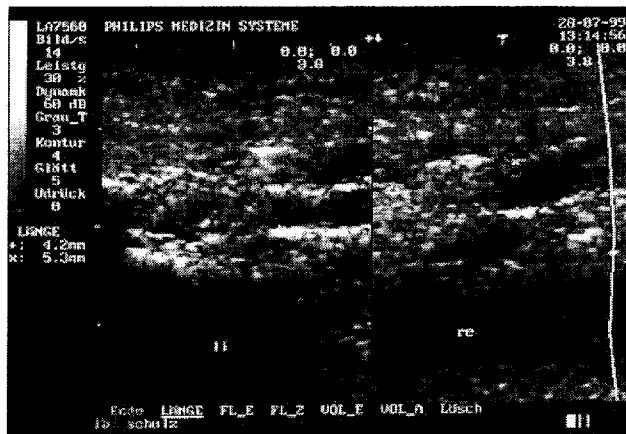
Ultrasonographic longitudinal appearance (linear scanner) of the plantar fascia. Asymptomatic left side with 4.2 mm thickness (+) and symptomatic right side with 5.3 mm thickness (x)
